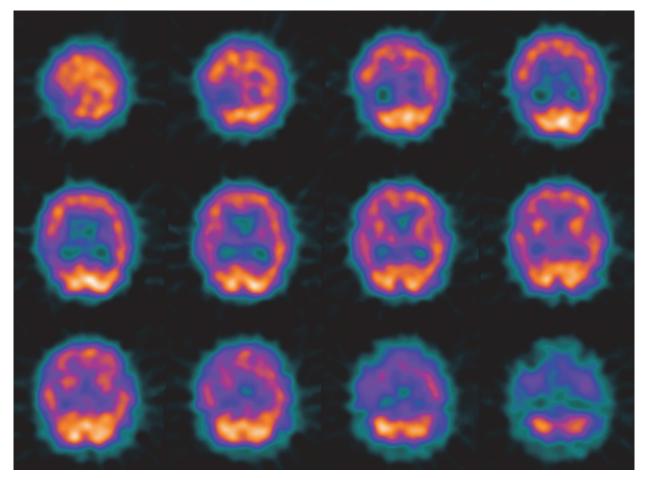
SPECT in AD. Transversal slices of a 99mTc-ECD SPECT study in a patient with early AD. Bilateral temporal hipoperfusion and assymmetrical parietal hipoperfusion, more evident on the right cortex, can be seen
